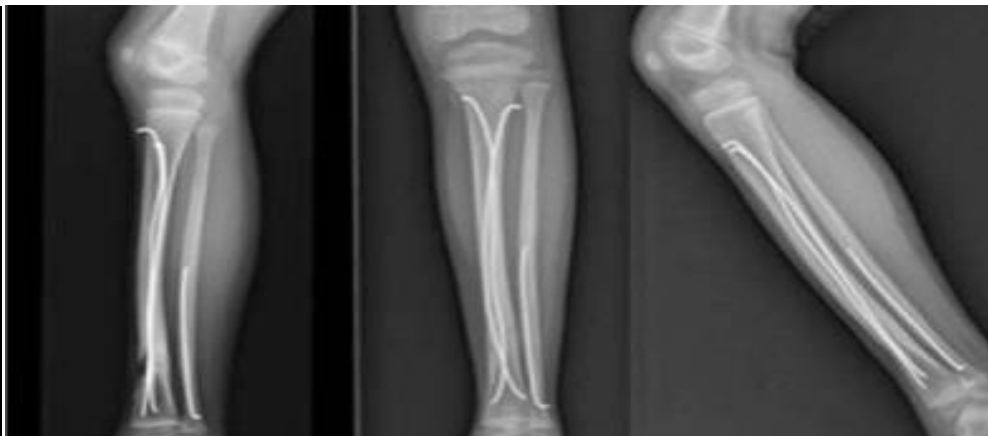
(d): Post-op X-Ray at 24 weeks
